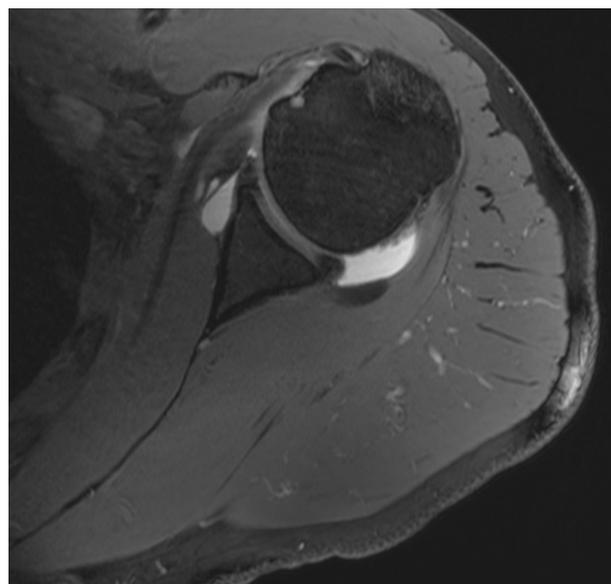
Axial magnetic resonance imaging shows a lesion of the subscapularis preoperatively.
